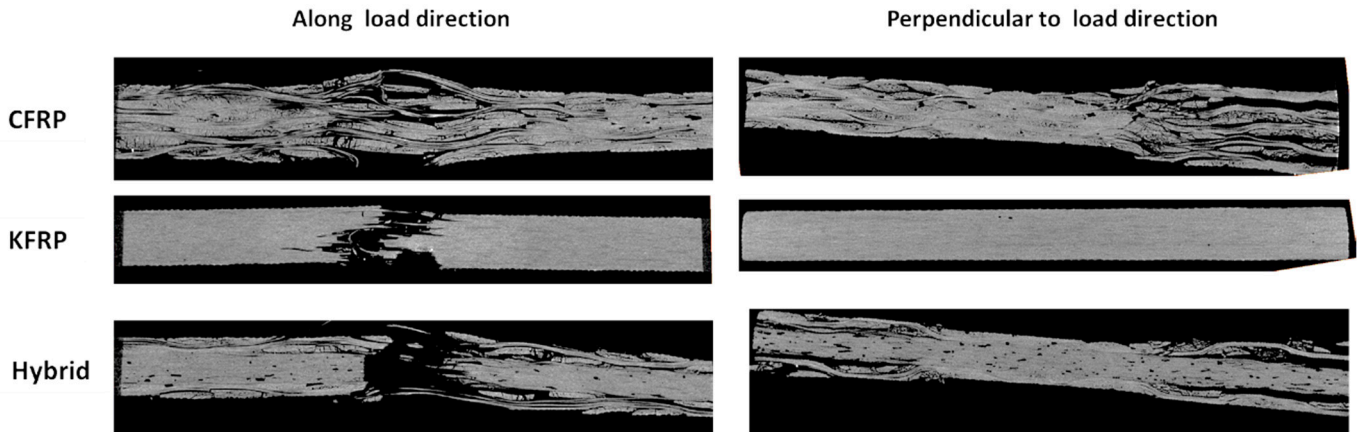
CT scan cross-section of failed open-hole tension samples with 12 mm hole diameters near the hole.
